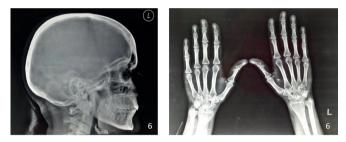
Normal lateral skull and hand and wrist radiograph with no evidence of demineralization.
